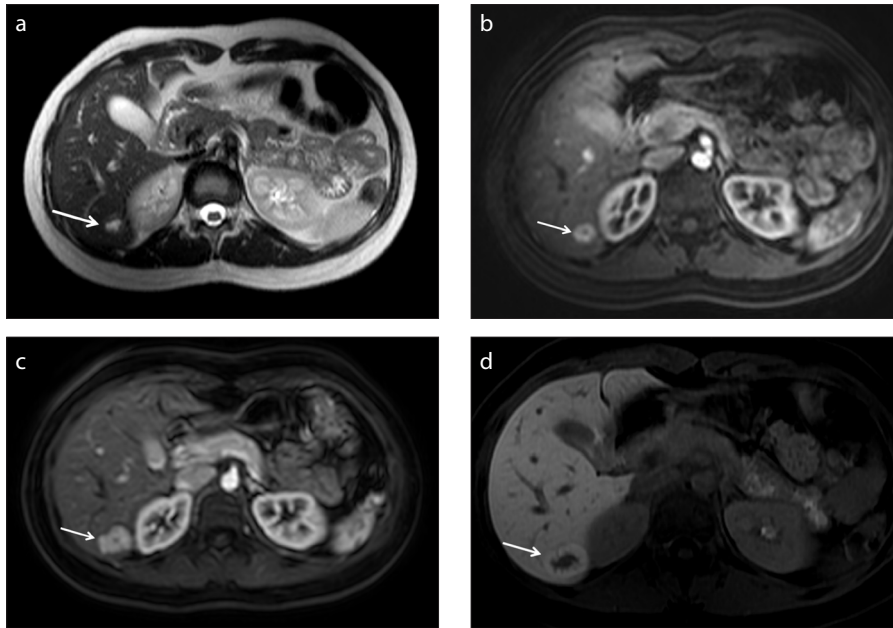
a–d. A 17-year-old girl with history of non-Hodgkin lymphoma. T2-weighted axial image (a) shows centrally hyperintense nodule in liver segment VI (arrow). On dynamic studies, lesion shows strong arterial enhancement during arterial phase (b, arrow). Gadoxetate disodium-enhanced MRI (c, d) performed 12 months later reveals lesion growth (arrow). Nodule appears hyperenhancing on arterial phase (c, arrow) and hyperintense (ring enhancement) on hepatobiliary phase (d, arrow).
